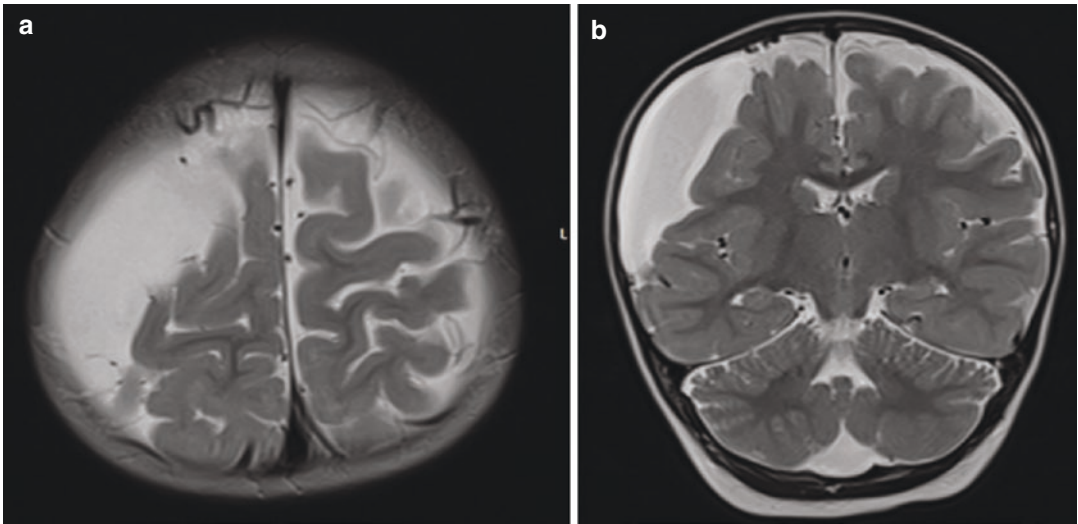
A 42-year-old female case. Asymptomatic, incidentally detected right temporal cystic lesion. Axial and sagittal views of T2-weighted sequence MRI. Differentiation between arachnoid and porencephalic cysts can be difficult
